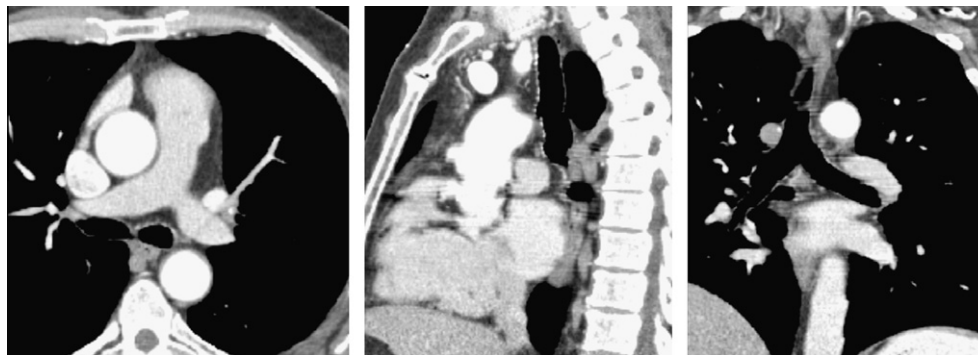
Axial, sagittal and coronal slice through the region of interest of a CT scan.
